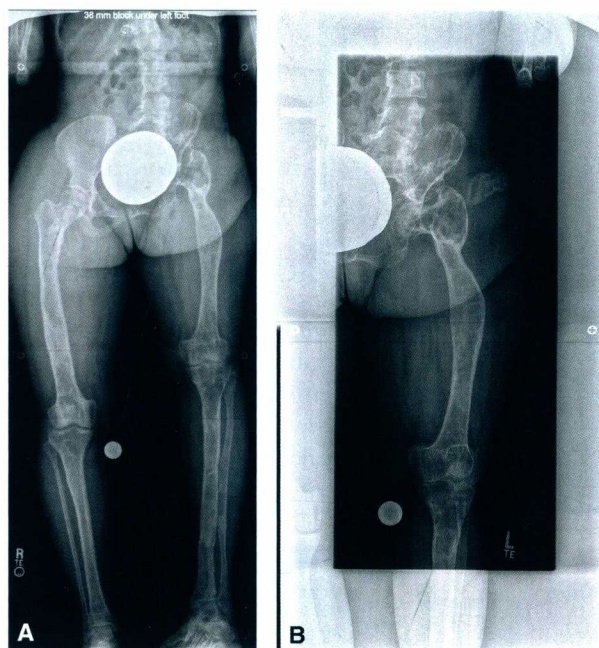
Radiographic pattern of fibrous dysplasia. Frontal X-ray of the lower extremities (A) and left femur (B) demonstrates expansile lesions with characteristic ground glass matrix, thin cortices, and bowing deformities. Not atypically, polyostotic fibrous dysplasia affects one side more than the other.
